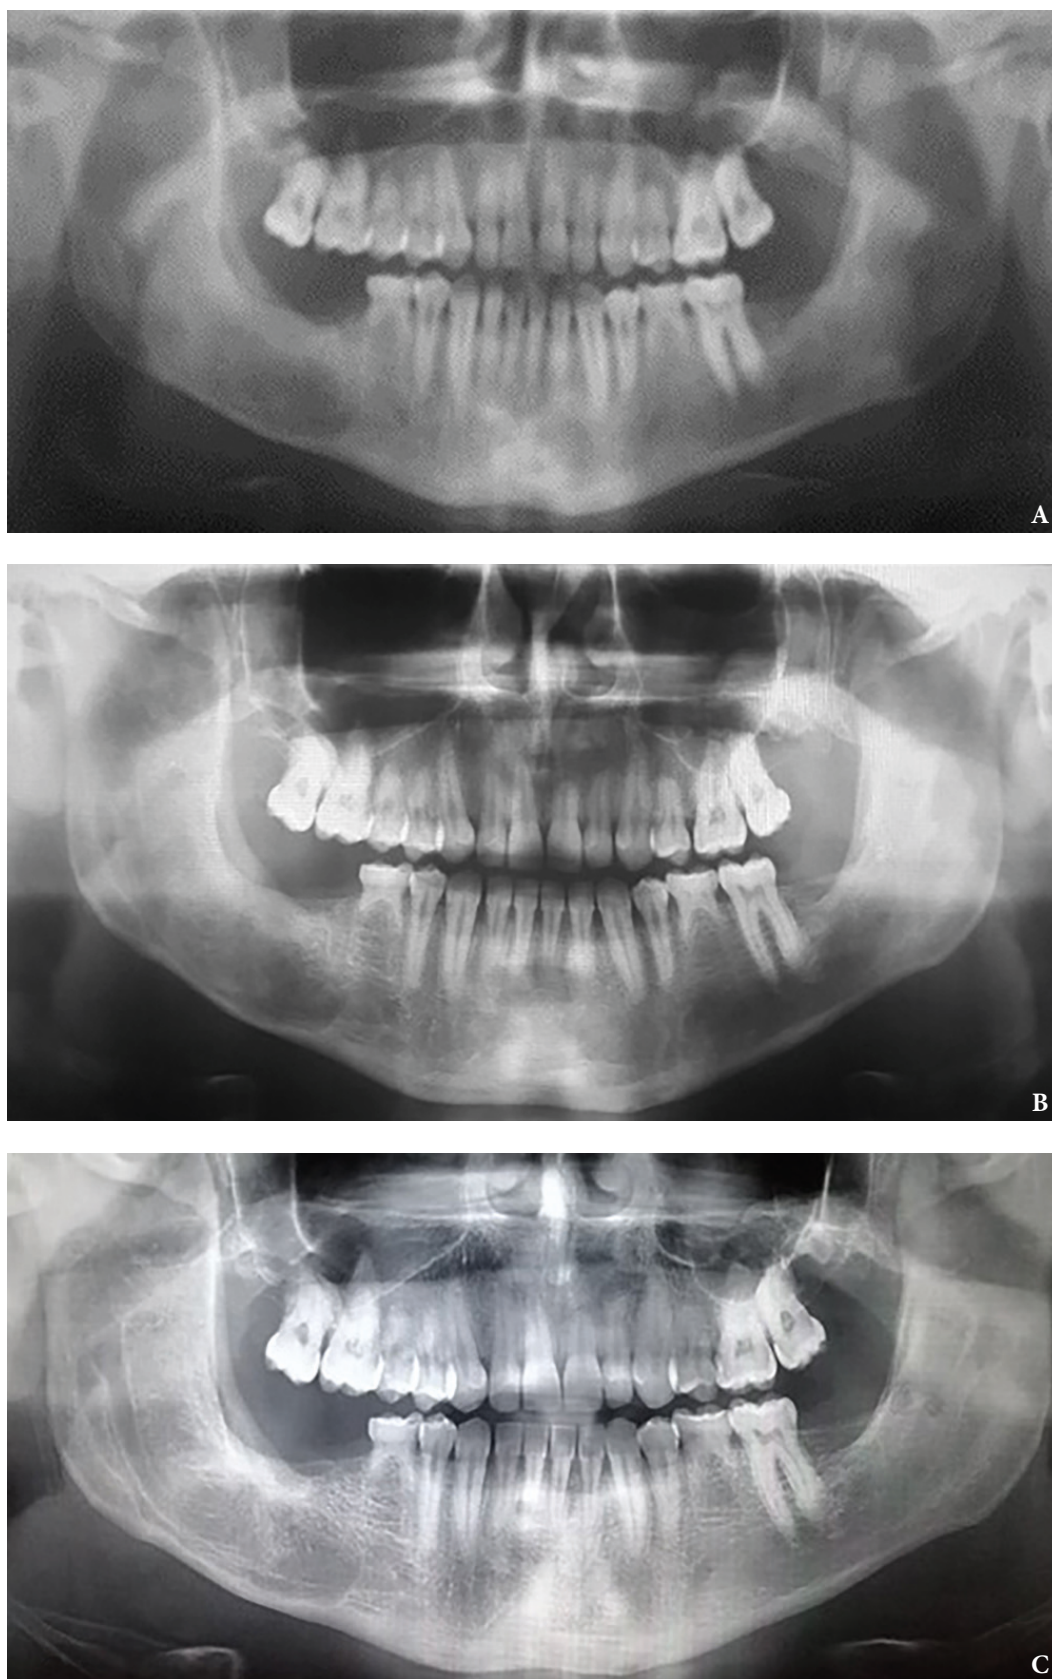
Case 6: Panoramic radiography. A: 7 months post-op. B: 1 year post-op. C: 2 years post-op.
